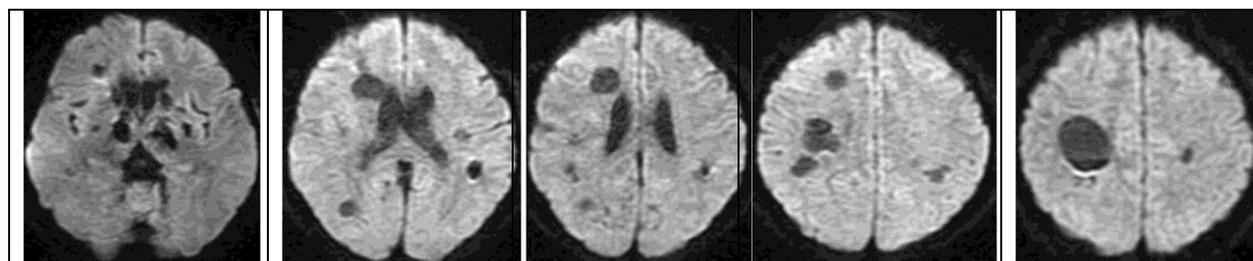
(A-E): DWI show no restricted diffusion.
